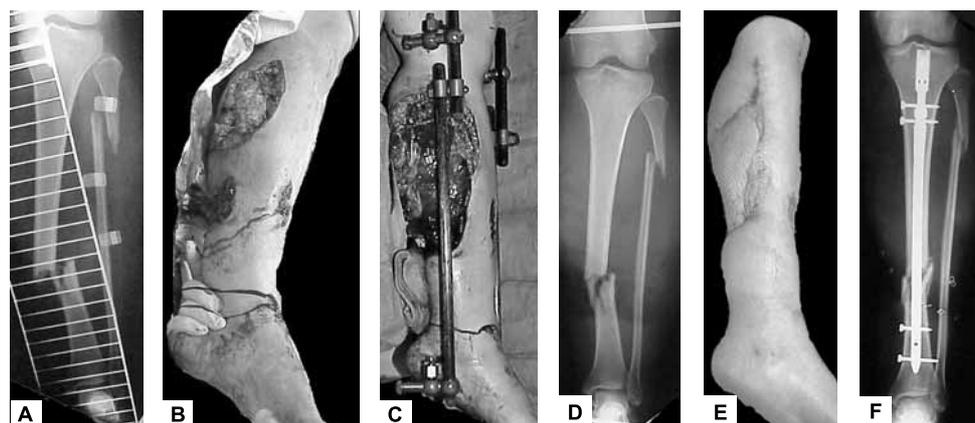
A. X-ray of midshaft comminuted tibia fracture and high fibula fracture. B. Clinical photo on admission presenting posteromedial soft tissue defects. C. Photo after debridements and "traveling" external fixator frame in place. D. Proximal pin is in distal femoral condyles, distal pin into calcaneus. E. Clinical photo of healed soft tissues after local soleus muscle flap and fasciocutaneous flaps have been used. F. X-ray of healed fractures with locked intramedullary nail. Nailing was performed fifth day after injury, immediately before soft tissue coverage with local flaps.
